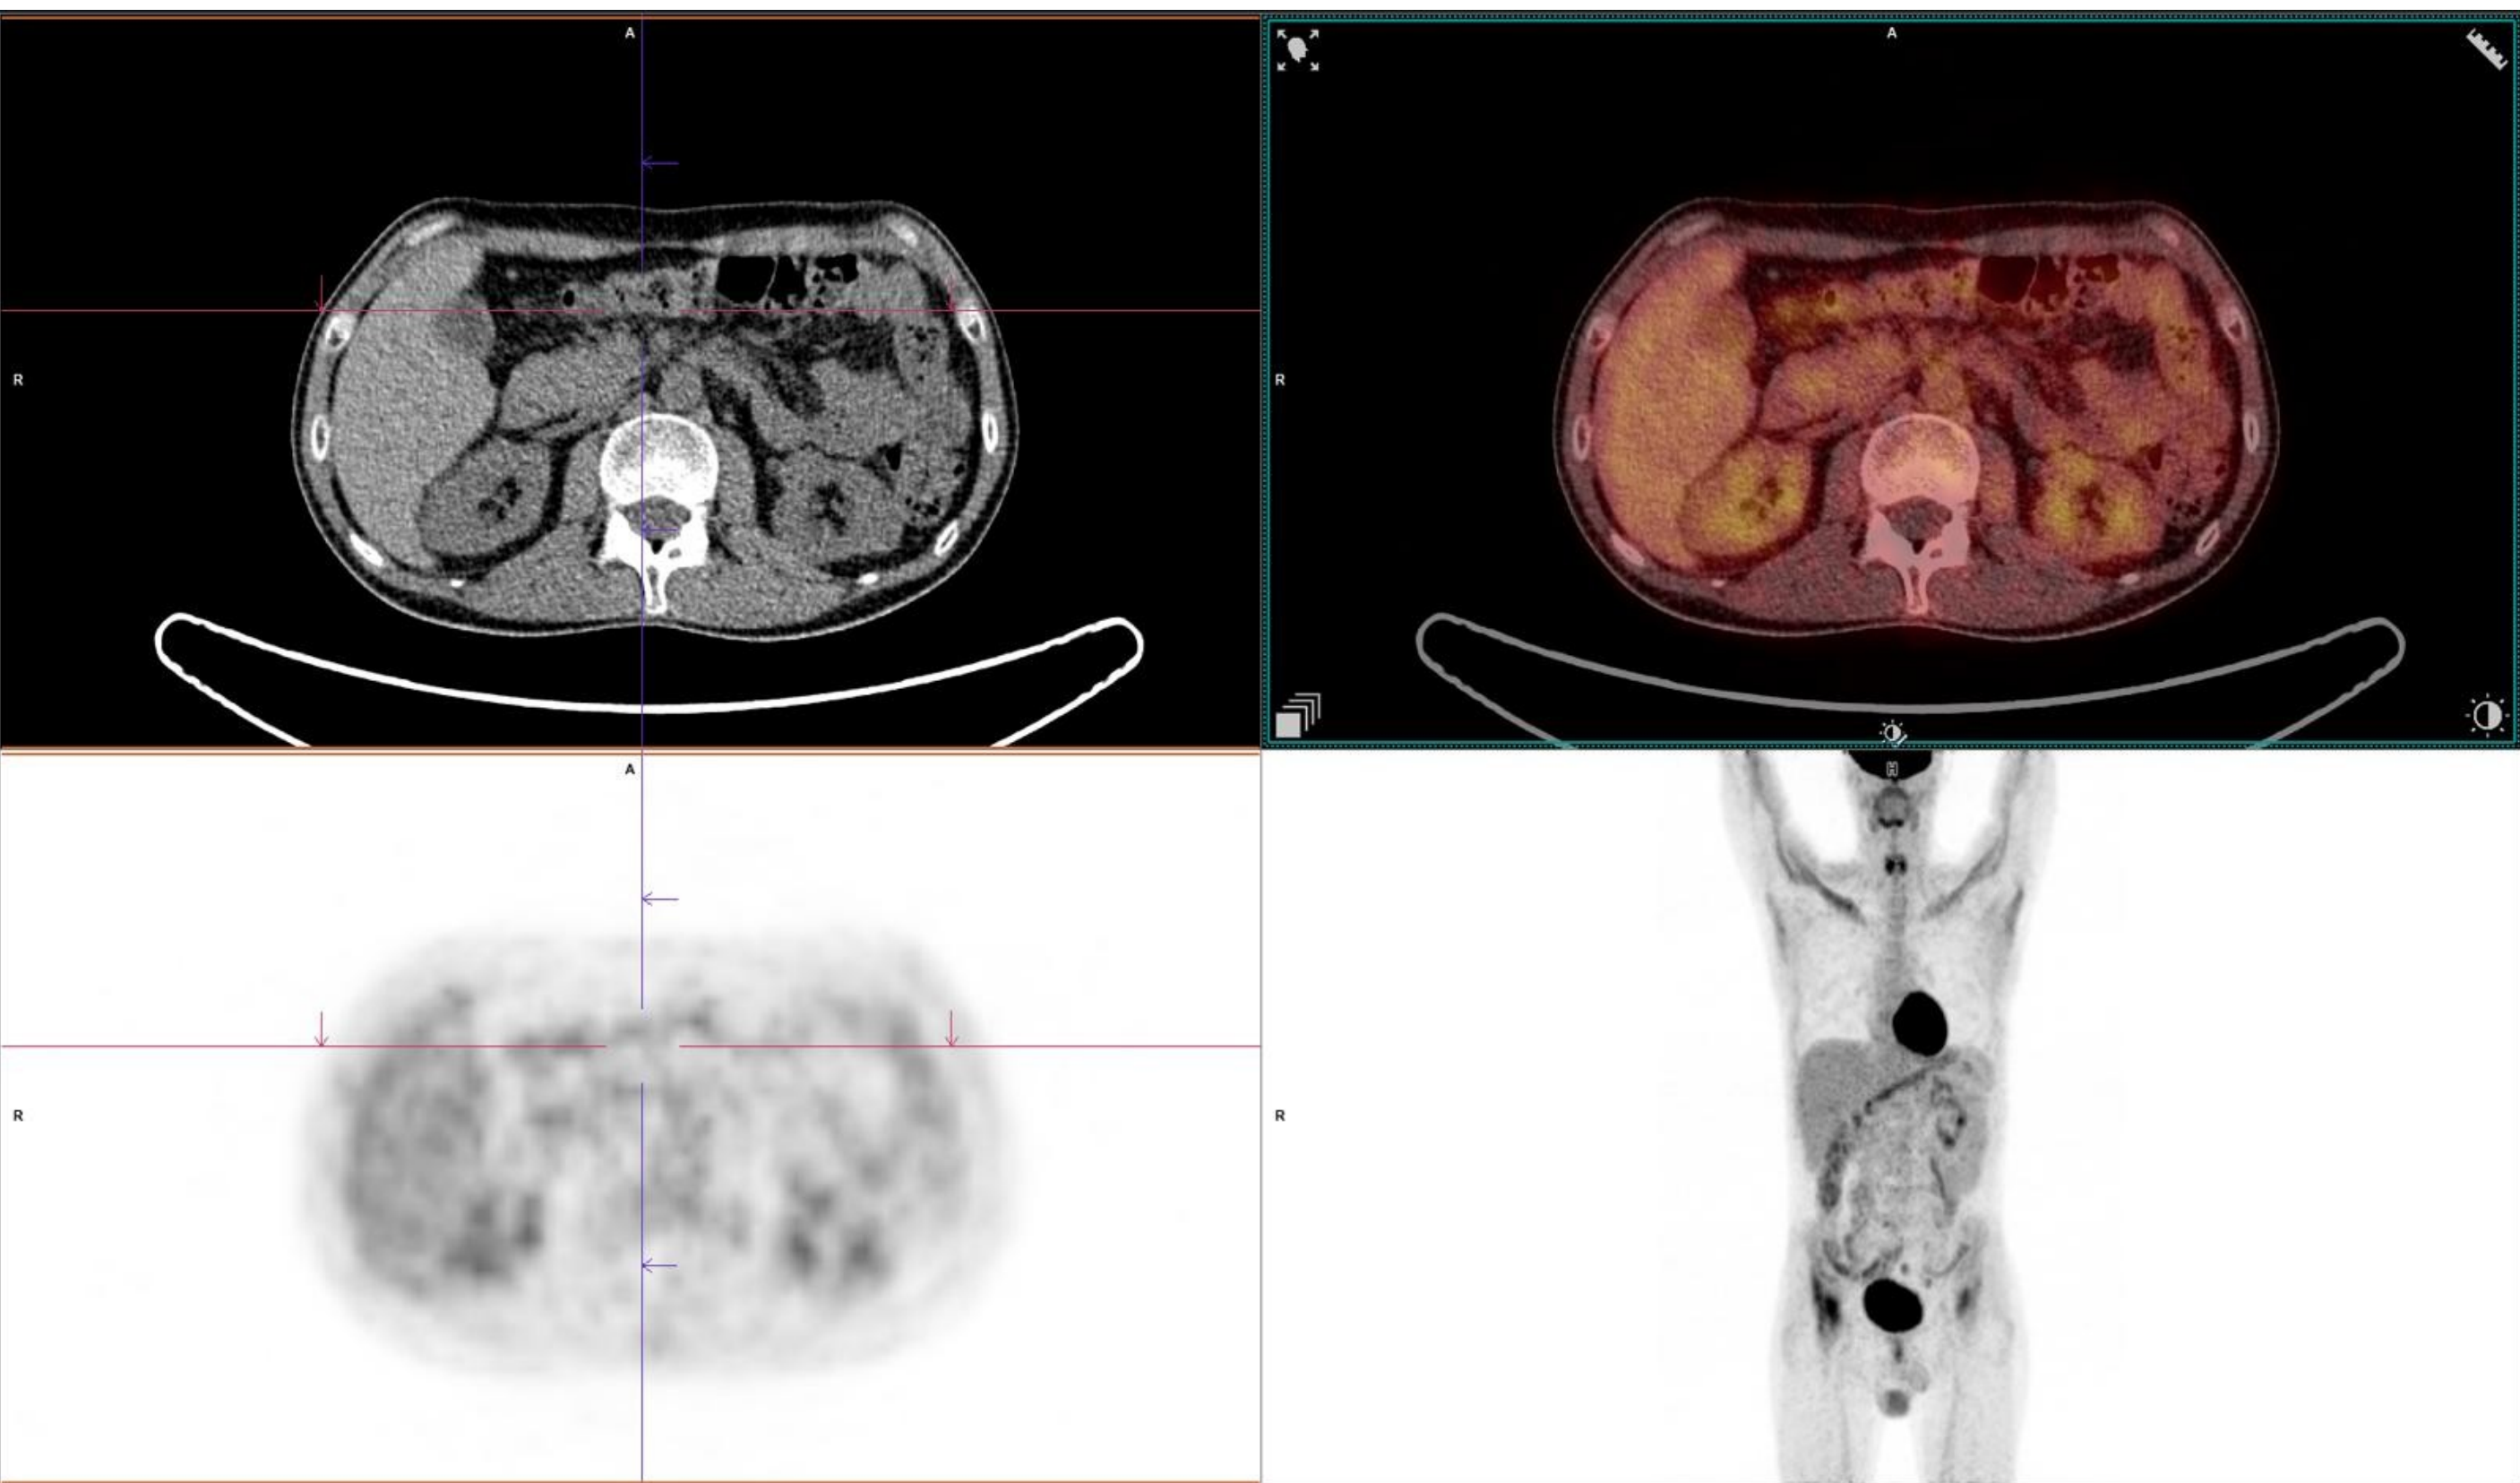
PET/CT performed one year after allogeneic stem cell transplantation shows no evidence of active disease
